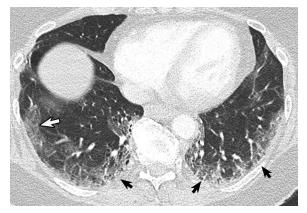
Peripheral ground-glass opacity (GGO) manifesting in a patient 5 days after symptoms of dyspnea, nausea, and body aches. Axial CT image shows faint rounded GGO (white arrow) in the right lower lobe laterally, with mild peripheral GGO in both lower lobes (black arrows).
